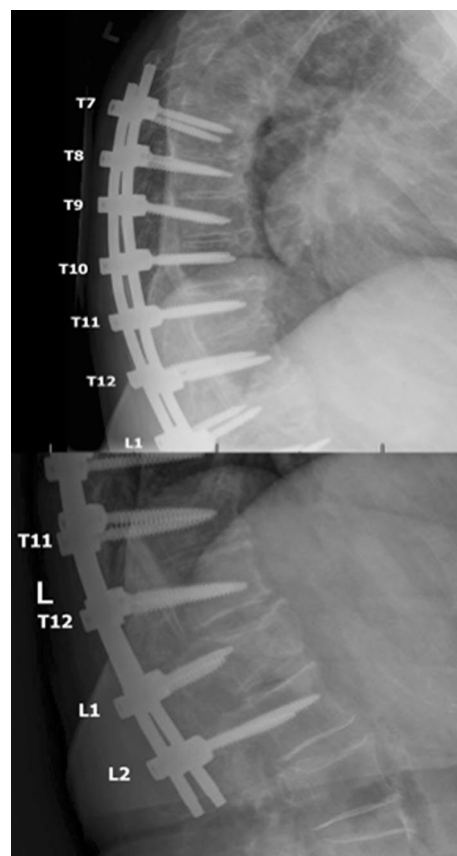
Postoperative lateral X-rays of thoracolumbar spine 6 months following T7-L2 PSIF showing the spinal fusion hardware properly in place and near-anatomic alignment of the spine
